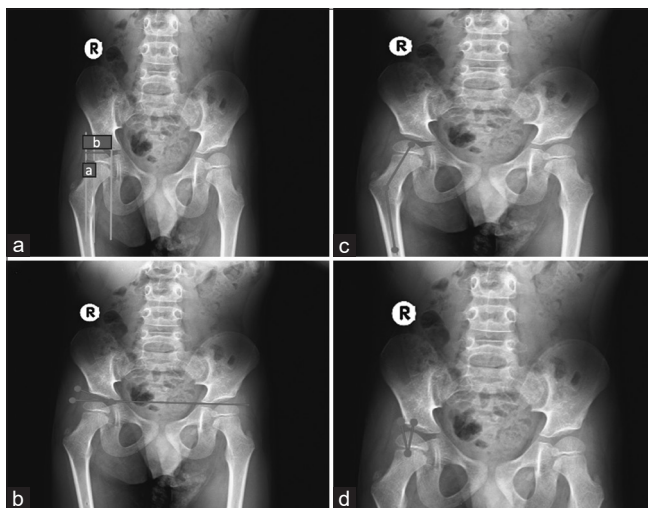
Measurements of radiographic parameters. (a) Measurement of the right hip migration index, (b) measurement of the right hip acetabular index, (c) measurement of the right hip FIA, and (d) measurement of the right hip lateral center-edge angle. FIA: Femoral inclination angle
